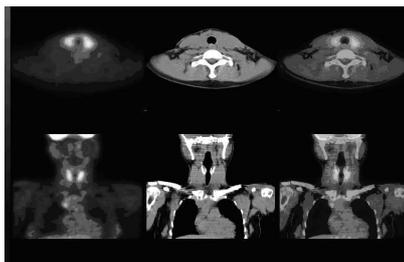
Benign diffuse incidental thyroid lesion identified by FDG PET imaging in a patient with a mediastinal mass.
